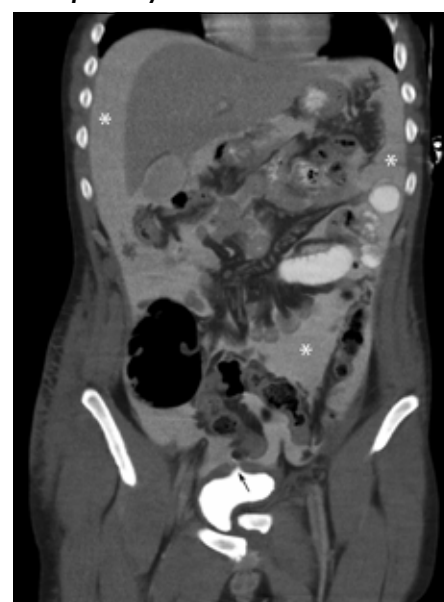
Sagittal computed tomography reconstruction demonstrating an intraperitoneal bladder dome rupture (black arrow) with active extravasation of urine into the peritoneal cavity.
